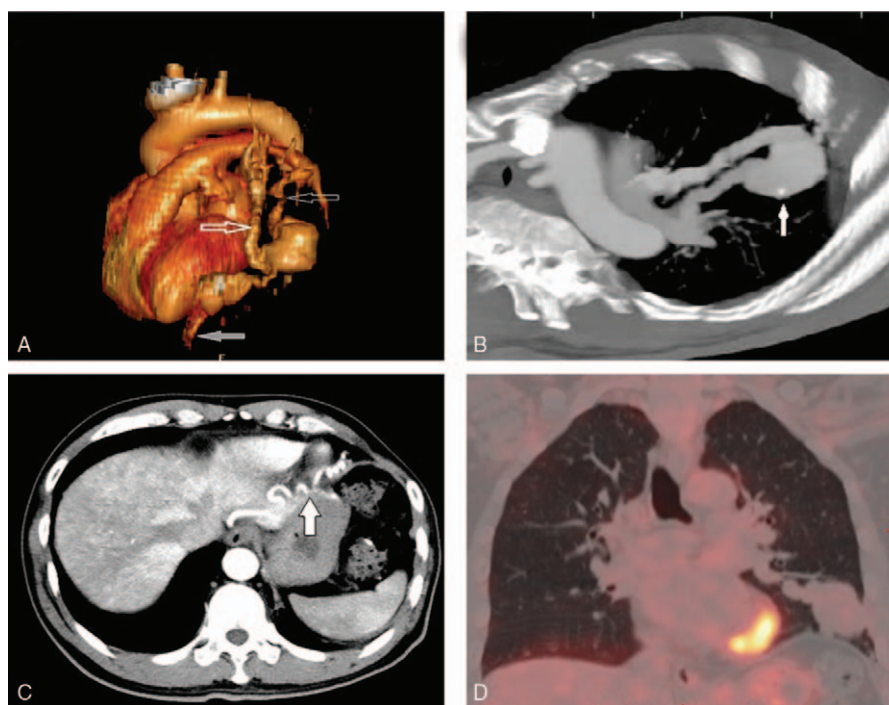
Chest CT vessel reconstruction showed abnormal branch vessel of the pulmonary arteriovenous malformations (PAVMs; grey solid arrow), vein (white hollow narrow arrow), and artery (white hollow thick arrow) (A). Calcification was presents in the lesion (B). Lung-enhanced CT scan identified an abnormal tortuous vessel at the left diaphragm that connects the left PAVM and the left gastric artery and forms a systemic pulmonary artery anastomosis (C). F-18 fluorodeoxyglucose positron emission tomography with computed tomography (^{18}F -FDG PET/CT) revealed enlarged mass with no significant F-18 FDG uptake (maximum standard uptake value of 1.4) in the left upper lung lobe (D).
